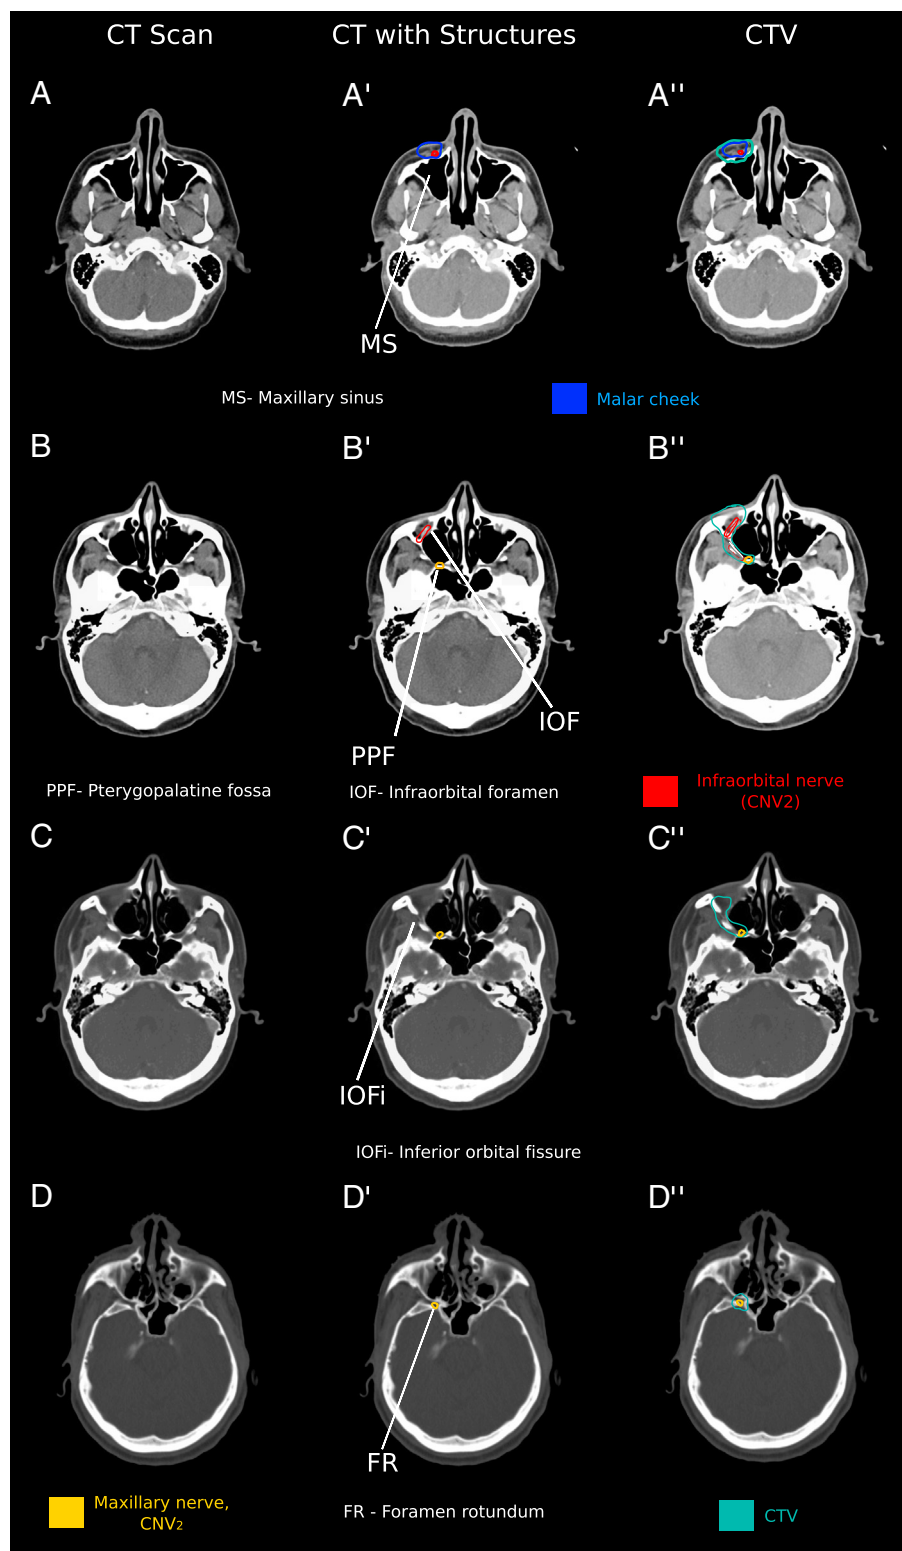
Axial computed tomographic (CT) slices of the malar cheek and related cranial nerves. The left column (A-D) depicts axial CT images of the area of interest, the middle column (A'-D') depicts the nerves contoured on CT images, and the right (A''-D'') depicts these contours with a clinical target volume (CTV; shown in teal). The maxillary nerve (cranial nerve [CN] V₂) (shown in yellow) and its branch, the infraorbital nerve (shown in red), provide innervation to the malar cheek (shown in blue) and are at risk for harboring cancer in the setting of perineural invasion.
